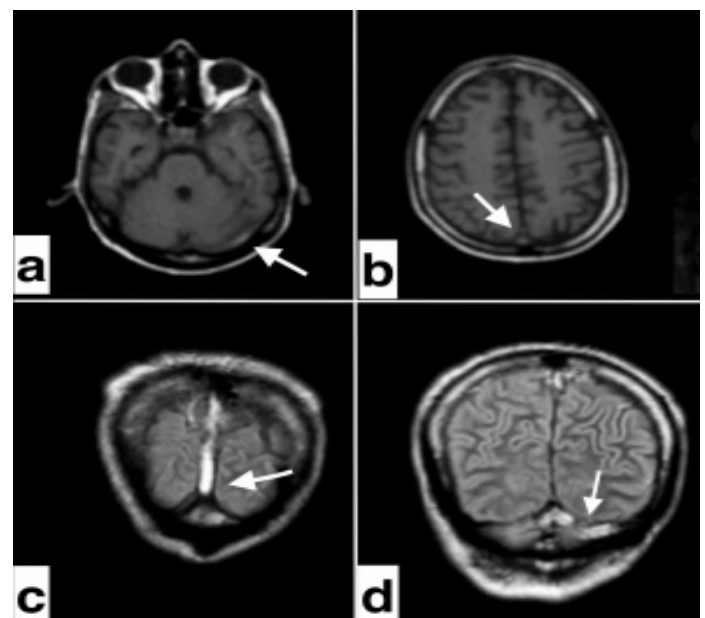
Patient (5 year old, boy) with superior and left transverse cerebral sinus thrombosis. Axial T1 weighted images (a,b) and coronal FLAIR images show hyperintense signal at left transverse (arrows in a and d) and superior sagittal sinus (arrows in b and c) consistent with thrombosis
